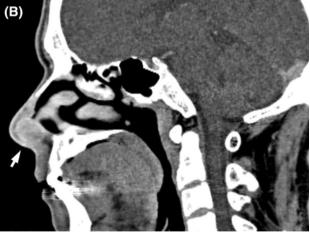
Transverse (a) and sagittal (b) contrast-enhanced computed tomography of paranasal sinuses showing a  $1.6 \times 1.8$ -cm enhancing lesion in the nasal septum (arrows)
